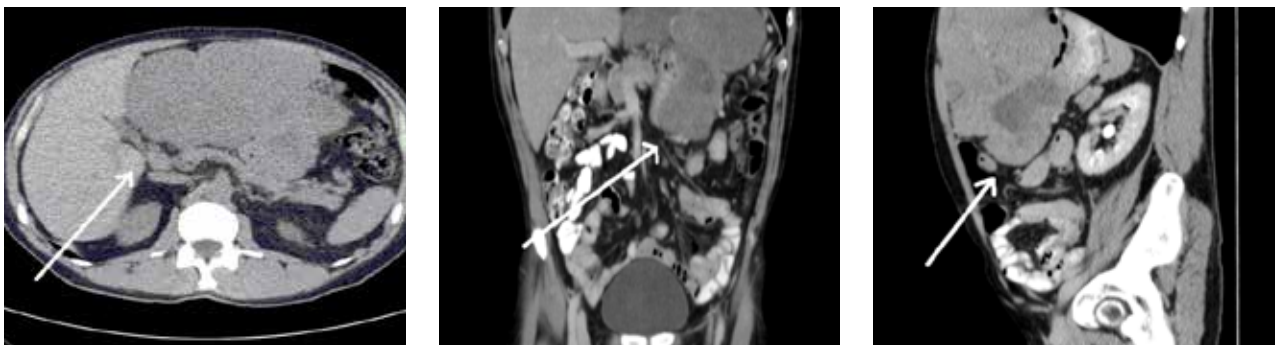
Gastric GIST, CT scan, a cross-sectional front sagittal section
